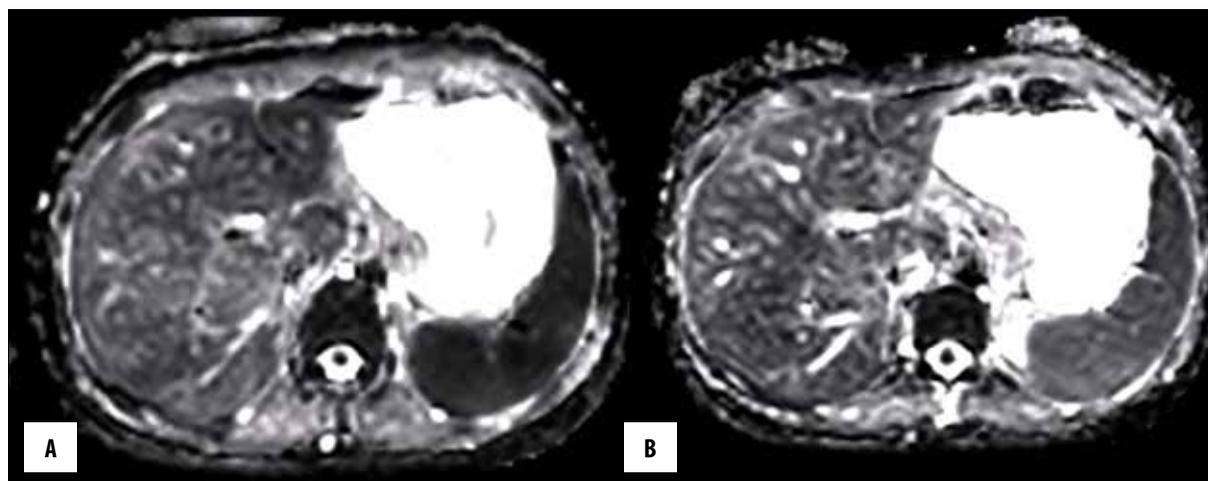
Breath-hold (A) and free breathing (B) ADC map images of a 25-year-old woman are shown. In this case ADC values were 1.35×10^{-3} mm²/s for the liver and 1.1×10^{-3} mm²/s for the spleen in BH DWI and 1.54×10^{-3} mm²/s for the liver and 1.3×10^{-3} mm²/s for the spleen in FB DWI.
